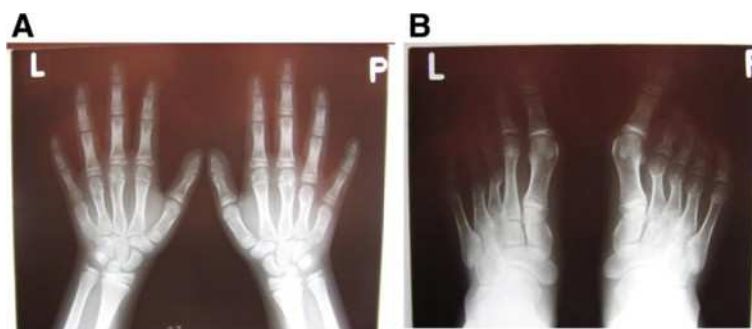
Radiographs of hands (A) and feet (B) of a non adult individual with heterozygous mutation in *HOXD13*(OMIM#113300) (courtesy of Dr. Aleksander Jamsheer). Shortening and widening of IV and V metacarpals are more evident in right; I, IV and V distal brachyphalangy, and mild clynodactyly of the distal phalanx of II and V, in left hand. In the feet, note asymmetrical shortening of the metatarsals: in right feet II, III, IV are shortened and in the left one, only III and IV. Note also, the clynodactyly of right hallux.
